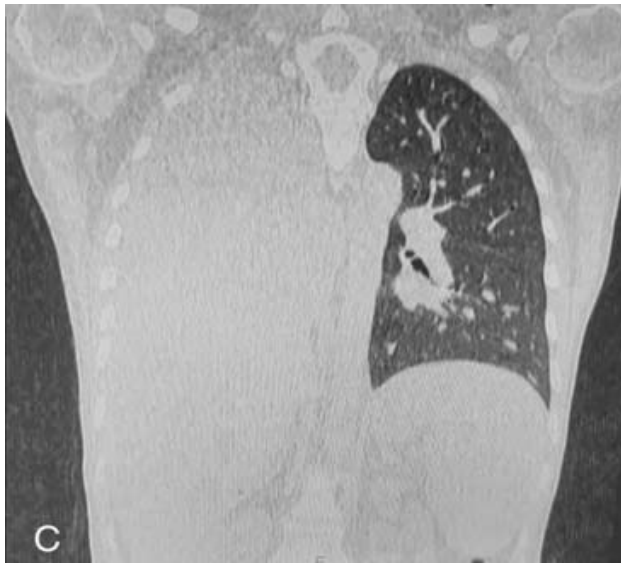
Chest CT coronal sections with (A) mediastinal precontrast, (B) mediastinal post contrast and (C) parenchymal window
